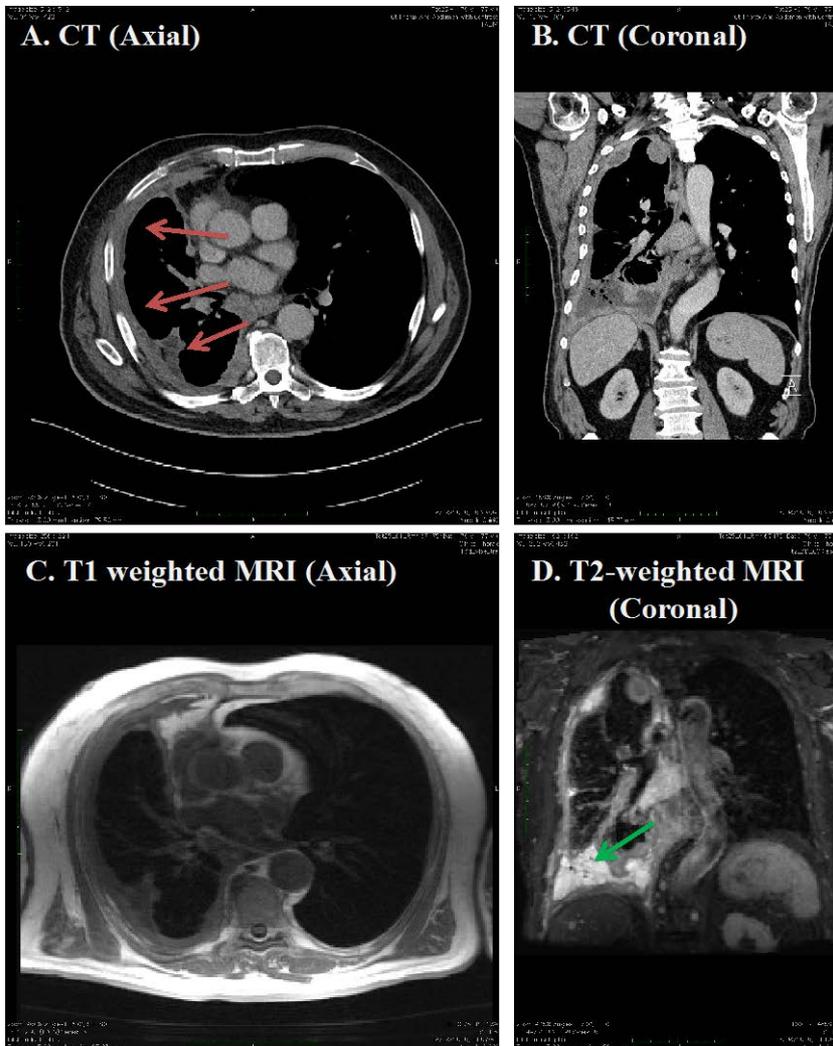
(A) Axial and (B) coronal reformat CT, (C) Axial T1-weighted and (D) Coronal T2-weighted MRI of a 77-year-old man with malignant mesothelioma of the right hemithorax.
